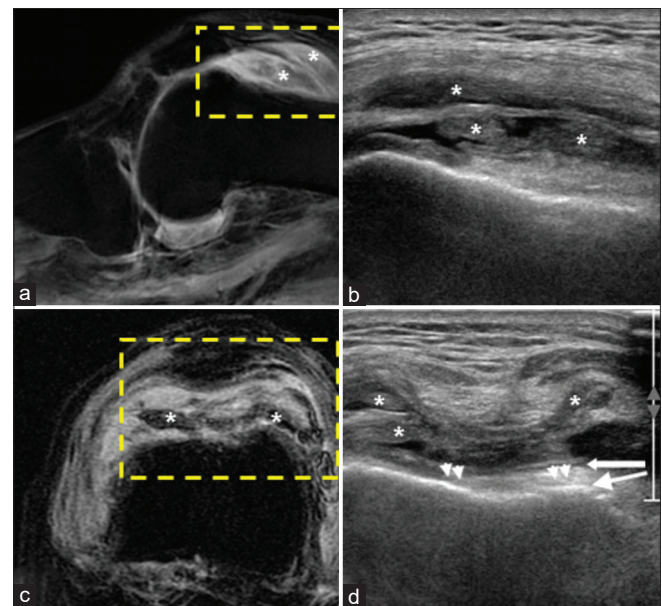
Ultrasound and magnetic resonance images of the patient's affected left knee at the similar level. (a) Magnetic resonance imaging proton density fat-suppressed sequence (sagittal) with high-signal intensity synovial proliferations with obscured internal contents (asterisk), (b) Ultrasound scan showing villus-like heterogeneous nodules. Septum-like structure separating the nodules (asterisk), possibly an embryologic remnant, a synovial plicae, (c) T2-weighted fat-suppressed gradient echo sequence (coronal) showing exaggerated low-signal intensity contents of the proliferated synovial nodules. The signal change from Figure 2a-c is characteristic of the hemosiderin components of pigmented villonodular synovitis in magnetic resonance imaging and is termed as “Blooming effect,” (d) Ultrasound scan at suprapatellar region along the short axis (almost corresponding to the yellow dash box) in (c) also reveals proliferated synovial tissue (asterisk) with fluid collection. Chondrocalcinosis (arrowhead) of the calcium pyrophosphate deposition is noted at the femoral condyle and in the X-ray. The arrow indicates the “cartilage interface sign” or “the double-contour sign of gouty arthritis” as one of the patient's past history
